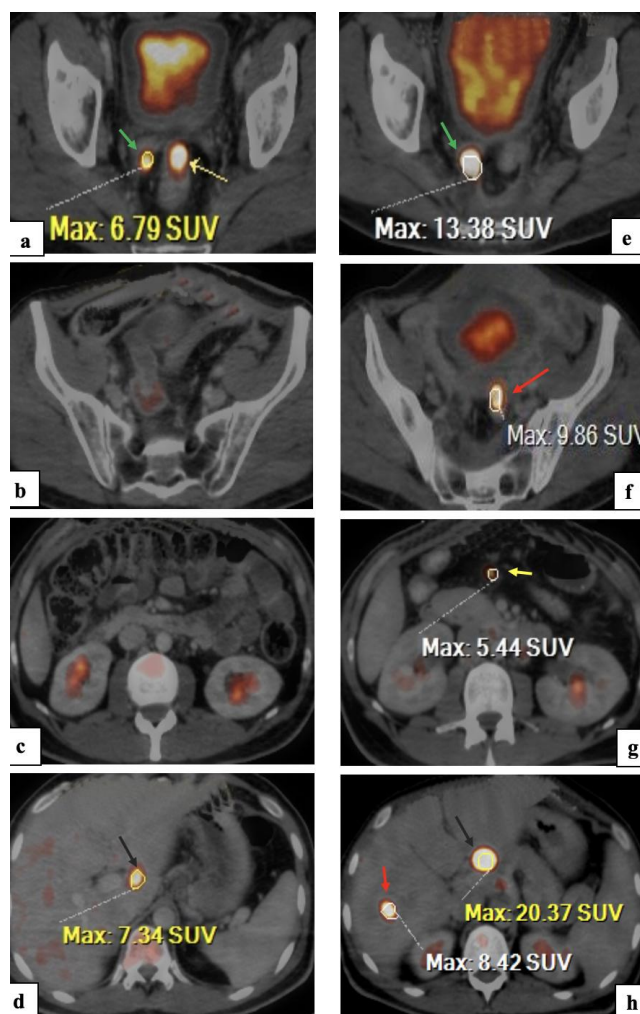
A 72-years old obese male patient, referred after resection of the recto-sigmoid mass and chemo-radiotherapy for follow up. Axial PET/CT images for two examinations; the first (a-d images) and the second examination (e, f, g, h images) after 4 months of treatment for comparison revealed; (a and e) progression of hypermetabolic peri-rectal soft tissue nodule achieving 13.38 SUVmax (6.79 SUVmax previously) (green arrow), while another lesion (yellow arrow image a) can't be detected in newly one (b and f) a small active hypermetabolic lesion (recurrent) is seen at the distal sigmoid colon, achieving 9.86 SUVmax (red arrow image f) (c and g) Newly developed a small hyper-metabolic peritoneal nodule is noted achieving 5.44 SUVmax (yellow arrow image g) (d and h). Metabolically and morphologically progression of porta-hepatis lymph node, achieves 20.37 SUVmax (7.34 SUVmax previously) (back arrow) and newly developed active right hepatic lobe focal lesion is seen (segment VI) achieves 8.42 SUVmax (red arrow)
